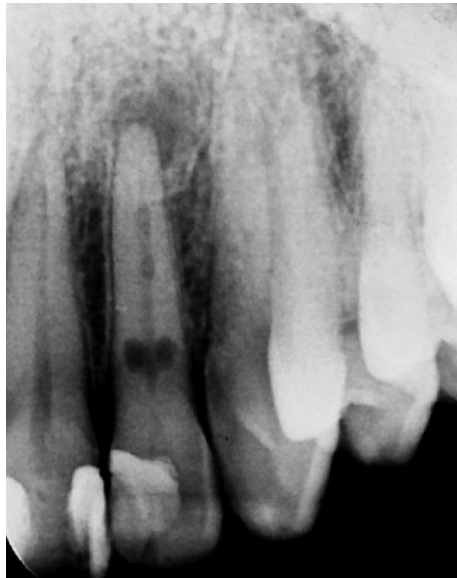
Initial radiographic
